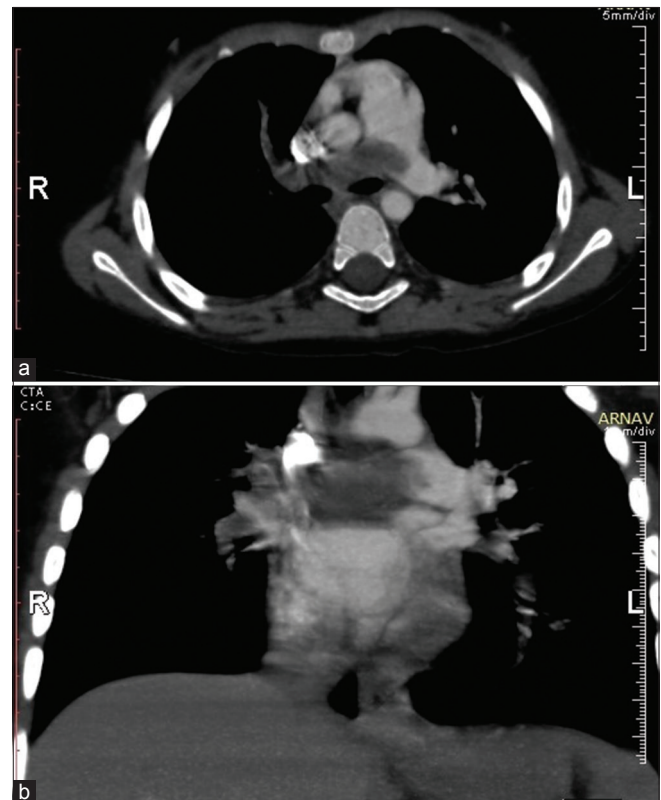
Computed tomography pulmonary angiogram (a) axial view and (b) coronal view: filling defect both at the bifurcation and in the pulmonary arteries suggestive of large saddle thrombus involving main pulmonary artery and its branches right and left pulmonary artery
